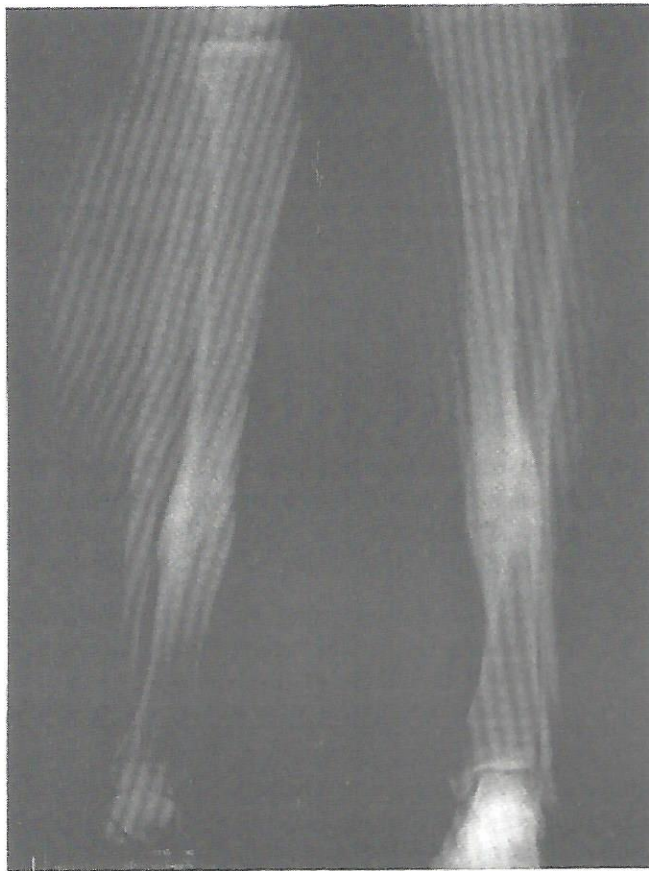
X-ray four years after conclusion of treatment with PEMF reveals persistent solid union.
